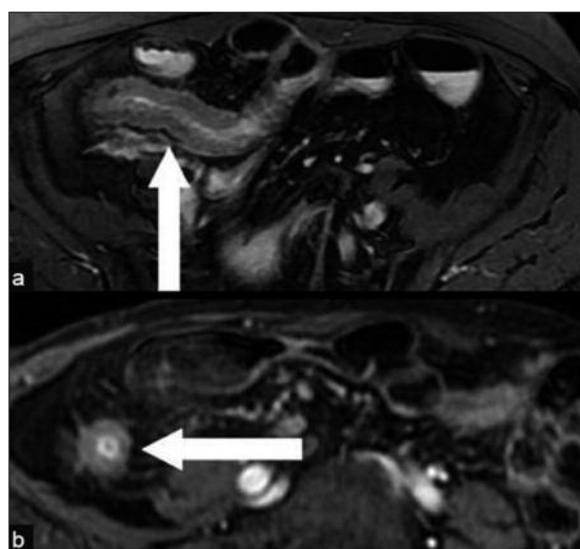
Magnetic resonance (MR) enterography showed active inflammation of terminal ileum. Marked thickening, abnormal high signal (a). High enhancement in T1-weighted sequences after intravenous administration of paramagnetic contrast medium (b).
